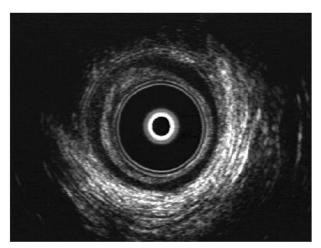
Transrectal ultrasonography (TRUS) showing a defect in external anal sphincter.
